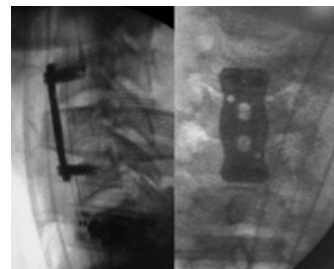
Shows the Intraoperative X-rays using C arm of the patient with C5 involvement.
